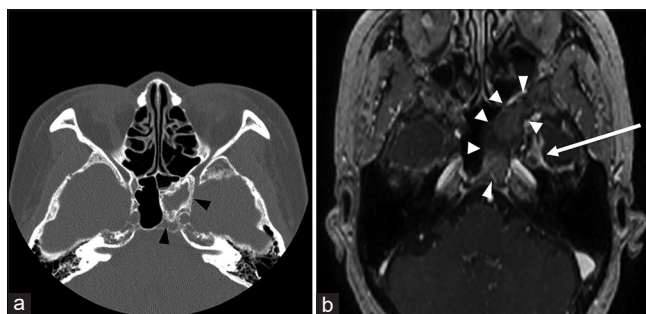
Sphenoid sinusitis. Prominent mucoperiosteal thickening is noted (black arrowheads) on computerized tomography (a). Left mandibular nerve with perineural enhancement is surrounded by engorged veins (white arrows) and isolated sphenoid sinusitis is indicated on contrast enhanced 3-dimensional fast spoiled gradient-echo T1 weighted image of magnetic resonance imaging (white arrowheads, b)
